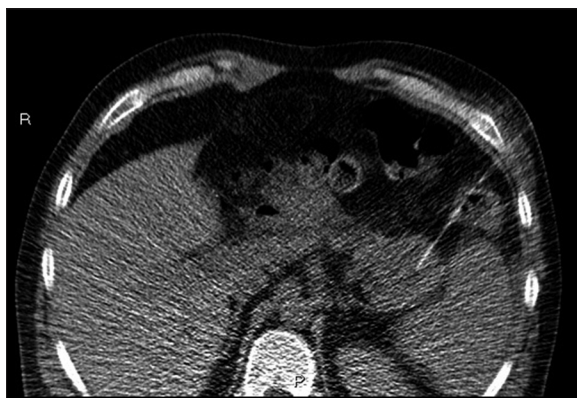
Axial scan during CT-guided procedure shows needle position inside the aneurysmatic sac before the injection of thrombin.
